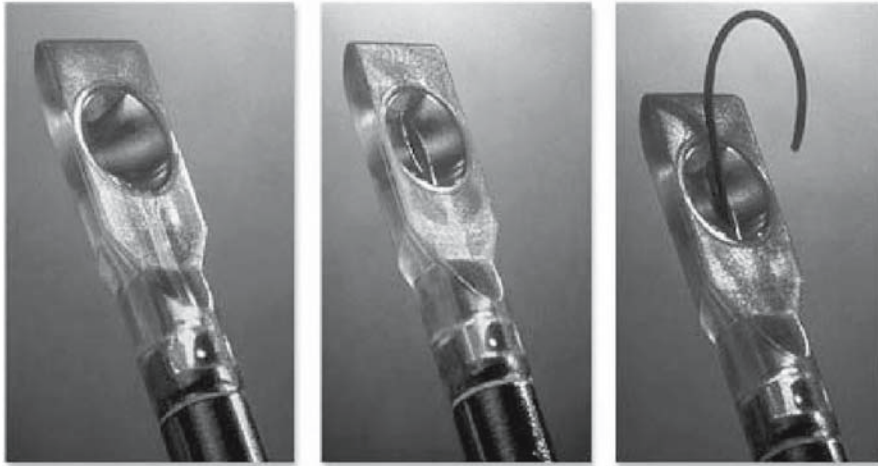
The PerDUCER instrument uses a sheathed needle with a suction tip designed for grasping the pericardium to access the pericardial space using a transthoracic approach, thus minimizing the risk of myocardial puncture.
